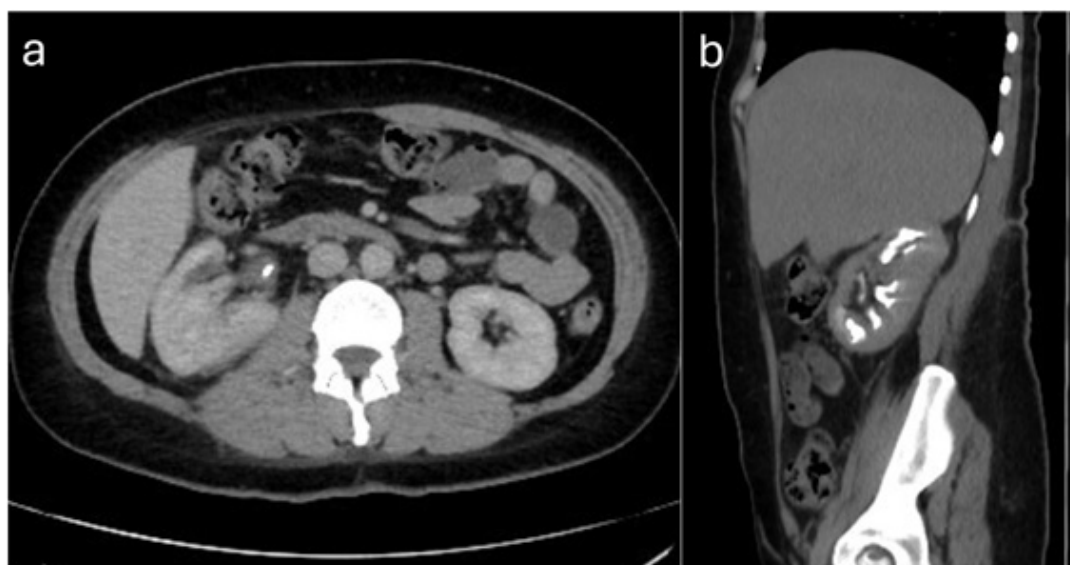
Axial contrast-enhanced CT scan and sagittal view during the excretory phase, acquired 60 days post-treatment, demonstrating complete resolution of the perirenal fluid collection and the absence of renal stones.
